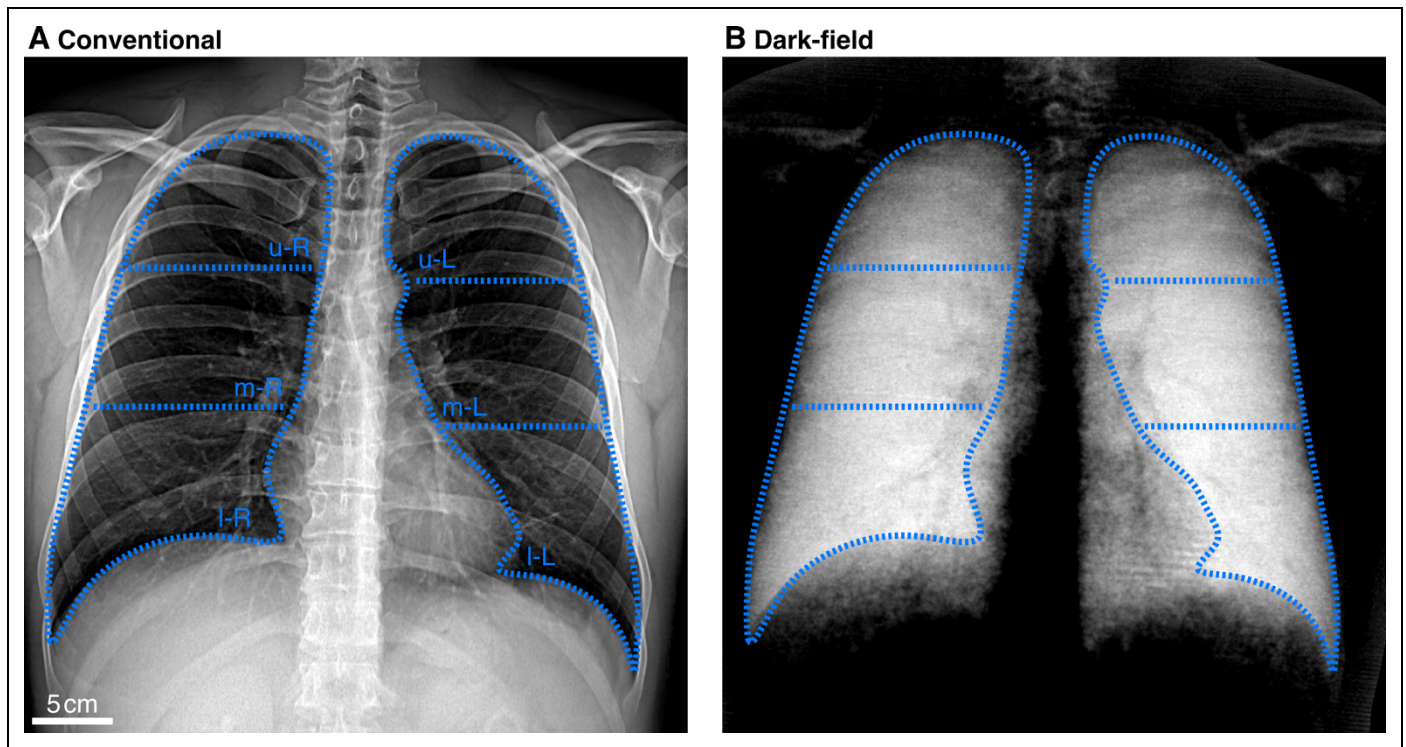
Exemplary lung masks generated manually for the statistical evaluation. Conventional (A) and dark-field (B) X-rays of the patient depicted in Figure 1 with superimposed lung masks. The masks were generated by manually tracing the boundary of the lungs in the attenuation image and splitting each lung into an upper, middle, and lower part. Heart and diaphragm regions were omitted. In order to obtain a reference measure for comparison with the reader ratings, the average signal from all coordinates lying within the boundary was calculated.
